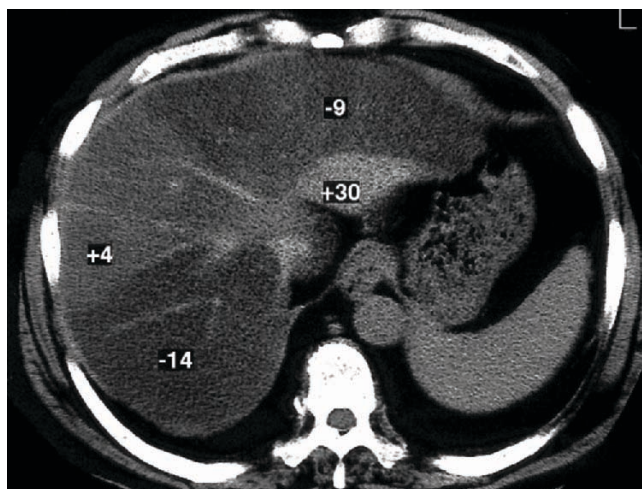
Pronounced focal (regional) fatty degeneration of the liver of varying intensity: both visual and confirmed by Hounsfield units (–14, –9, +4, +30). Native CT, normal value +65 HU
